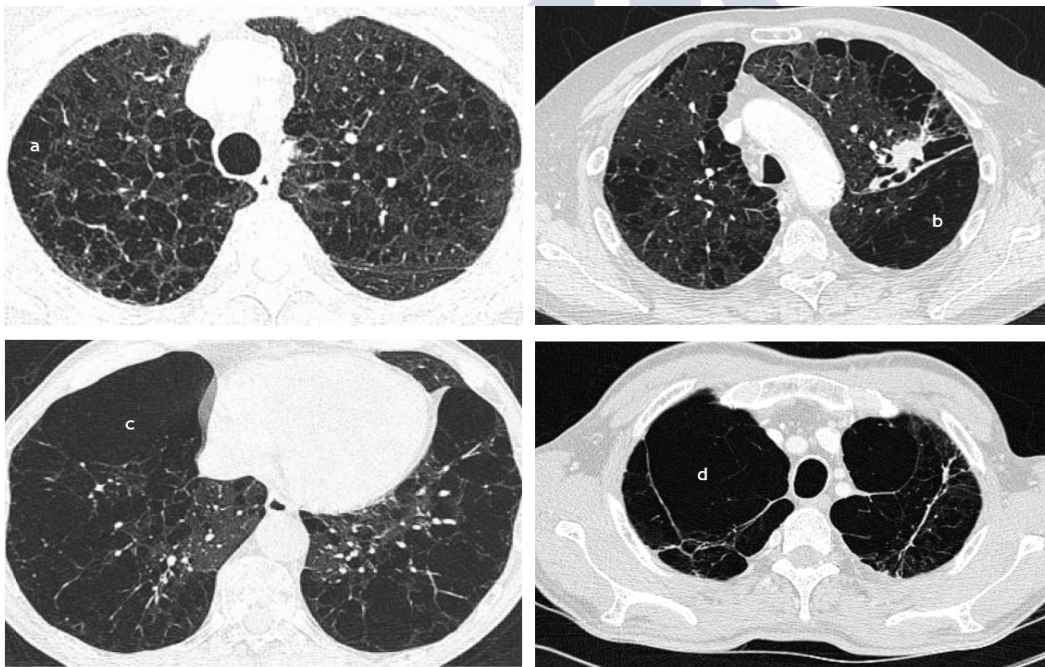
The four images in this figure correspond to four axial slices of a pulmonary CT. The first (a) corresponds to an image of centrilobular emphysema, the second (b) shows an area of paraseptal emphysema, the third (c) shows an image of panacinar emphysema, and the fourth (d) shows the existence of a pulmonary bulla. Figures (a) and (c) have been adapted from Hansel et al. Fleischner Society: Glossary of Terms for Thoracic Imaging. Radiology. 2008; 246 (3):697-722, permitted by Radiology, whereas Figures (b) and (d) belong to two patients in our database which gave specific written informed consent for the anonymized publication of their images..
